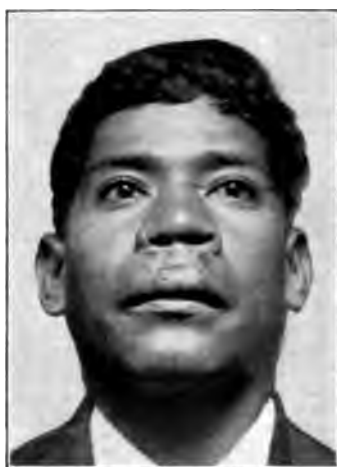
Same as Fig. 204, after x-ray treatment. (Courtesy of Dr. M. J. Wunderlich.)
